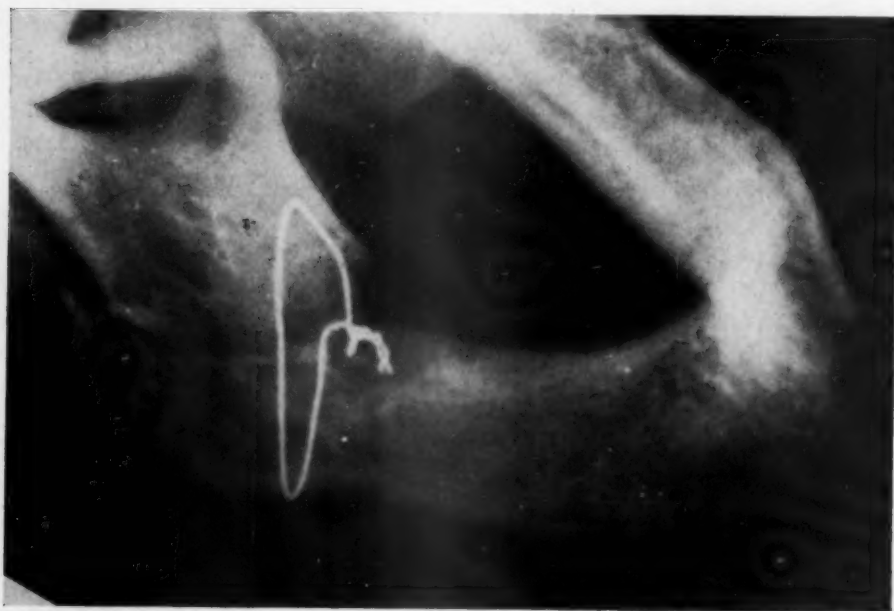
Postoperative x-rays showing reduction and internal wiring fixation.
